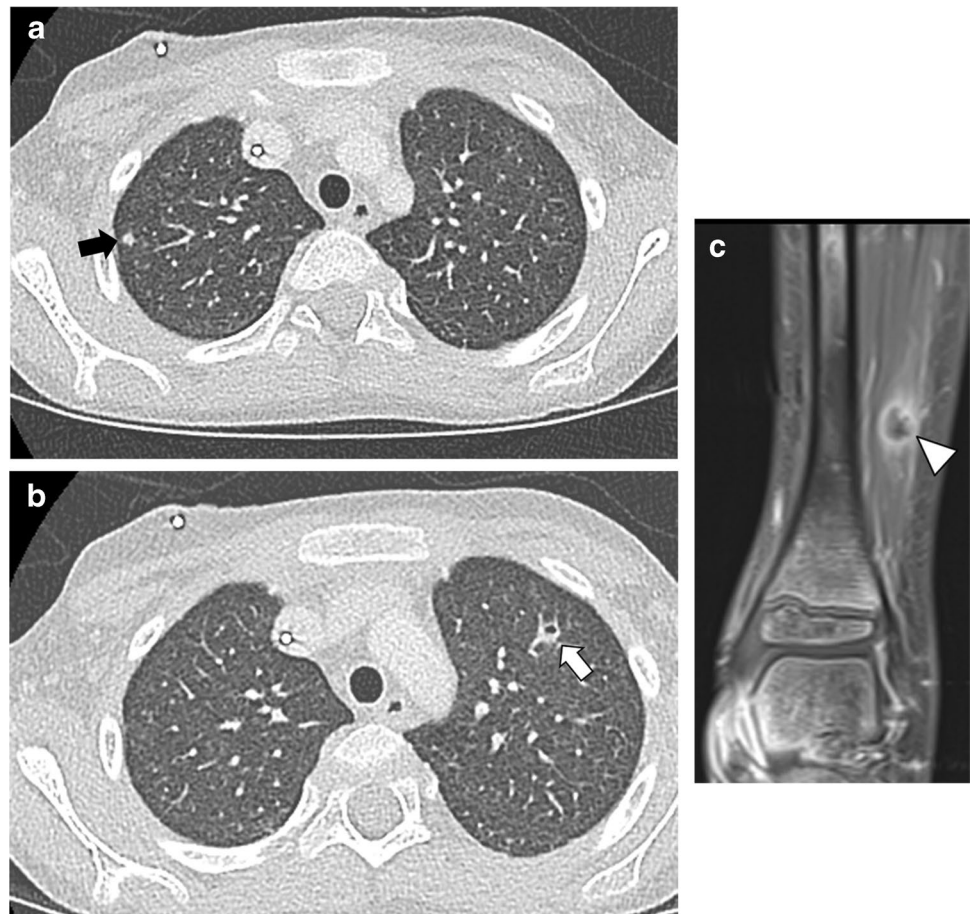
Invasive pulmonary aspergillosis in a 17-year-old girl with relapsed acute myelogenous leukemia (AML) post hematopoietic cell transplant, on salvage therapy undergoing evaluation for chimeric antigen receptor T cell therapy. a Coronal CT image obtained 1 month after start of therapy demonstrates the halo sign with a right
